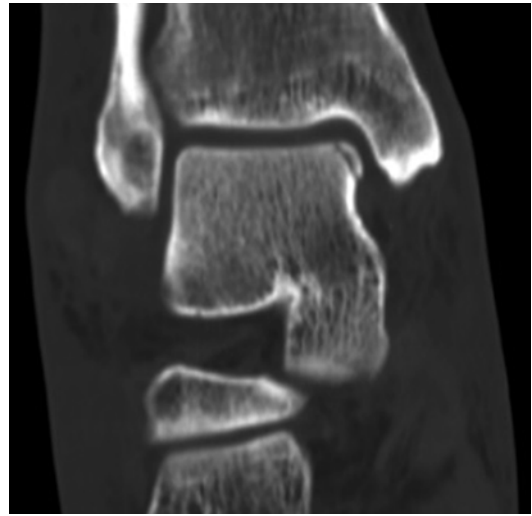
Coronal view of a CT scan performed for OCL preoperative evaluation. CT scan is very useful to improve subchondral bone visualization
